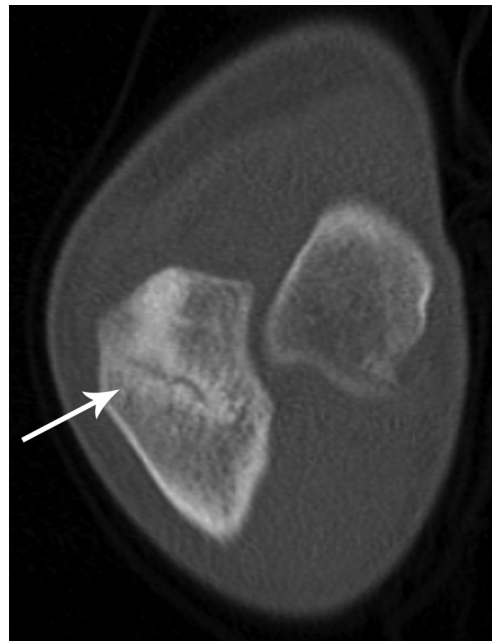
Axial slice of a CT scan of a professional pitcher demonstrating a stress fracture of the olecranon (arrow).
